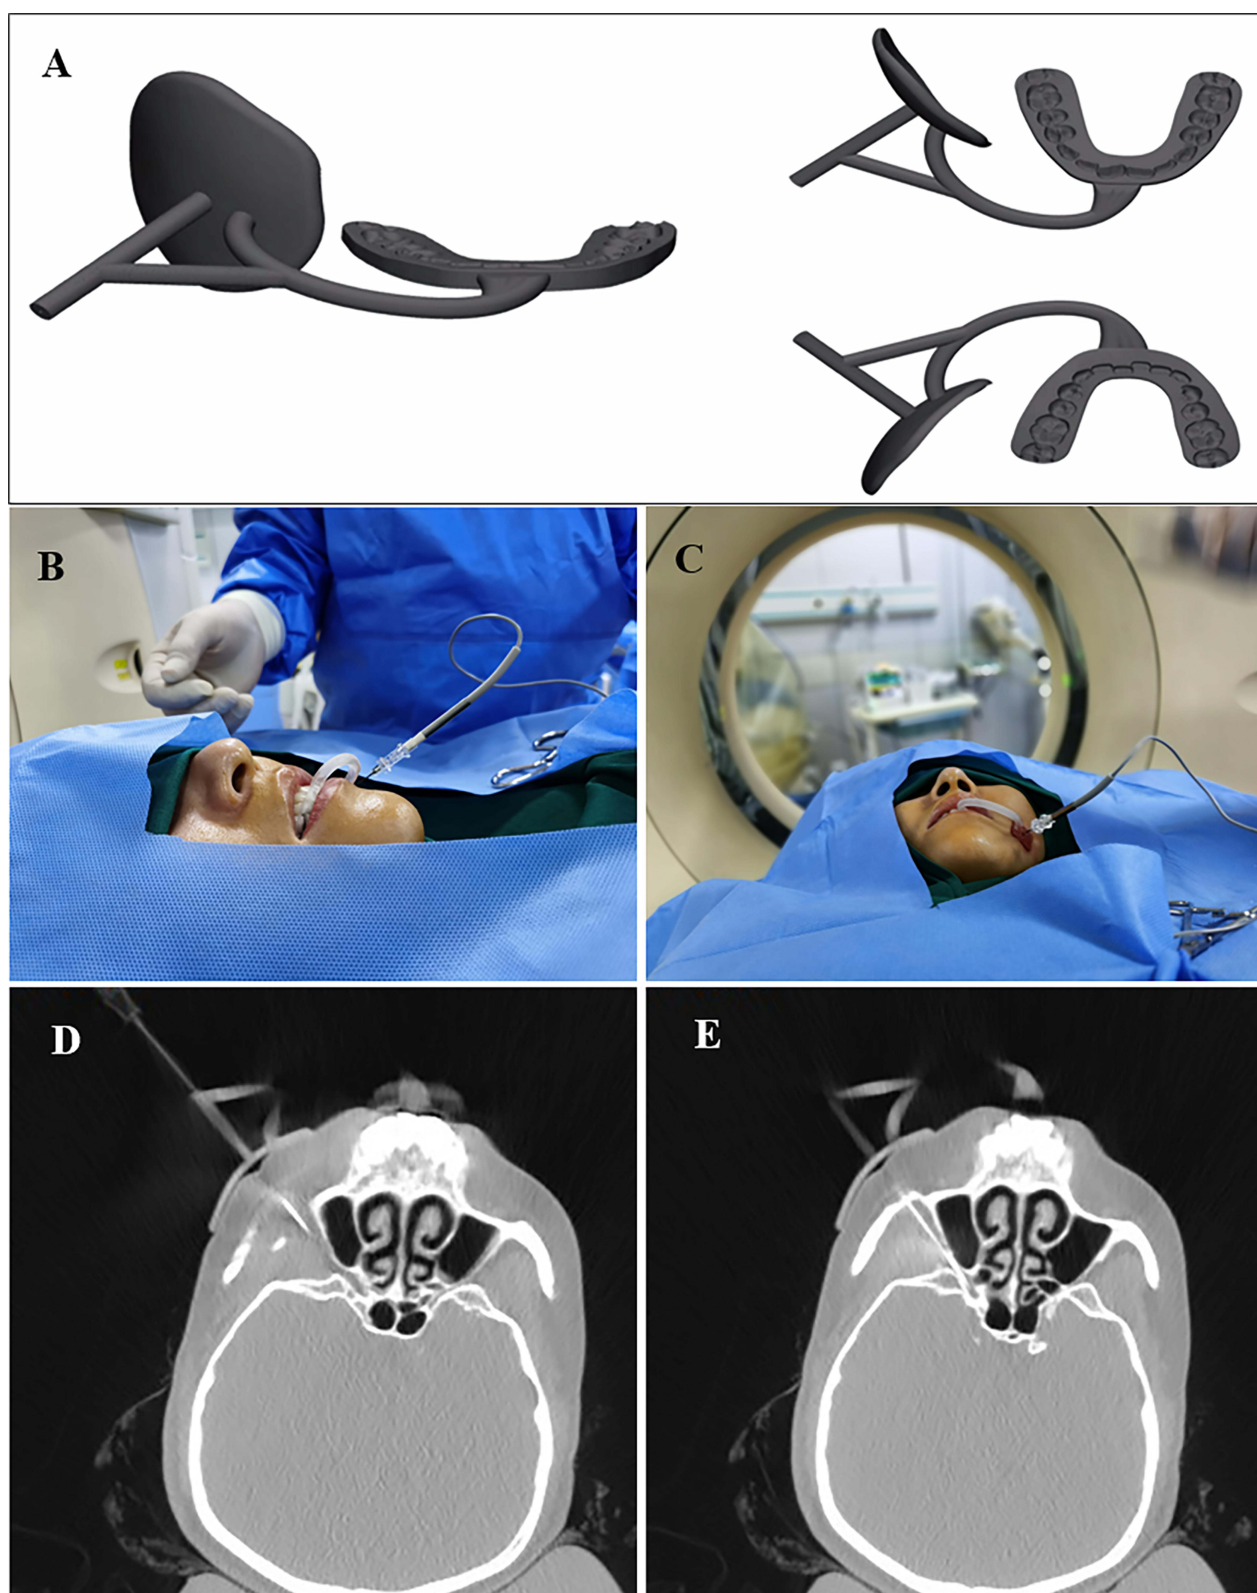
Clinical application of the 3D-PTST. (A) The 3D-PTST viewed from a different angle; (B and C) Use of a 3D-PTST on a patient in a clinical setting; (D and E) The tip of the radiofrequency needle was confirmed by CT. Abbreviations: 3D-PTST, 3D printed Tooth-supported Template.
